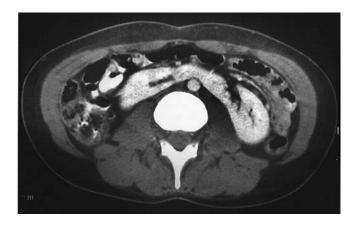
CT appearance of a horseshoe kidney. A bridge of tissue (isthmus) connecting the lower poles of both kidneys over the spine is visualized.
